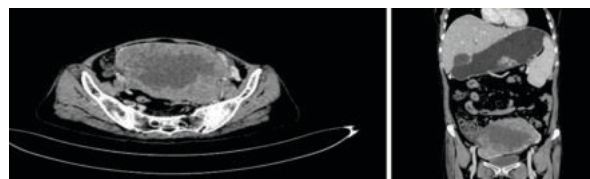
Contrast CT scan in axial and coronal view image depicting well-defined, lobulated, heterogeneously enhancing mass in the pelvic cavity, containing central non-enhancing necrotic areas likely arising from the left ovary.
